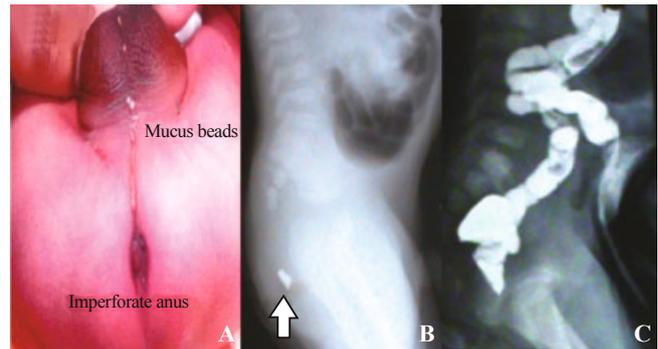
Clinical photograph showing absent anal opening with mucus beads in the midline raphe, suggestive of an anocutaneous fistula (low anorectal malformation); B: Lateral view of a prone cross-table X-ray showing distal most gas shadow above the pubococcygeal line, suggestive of high anorectal malformation (open black arrow indicates the marker at the site of anus); C: Distal cologram shows low termination of the bowel.
